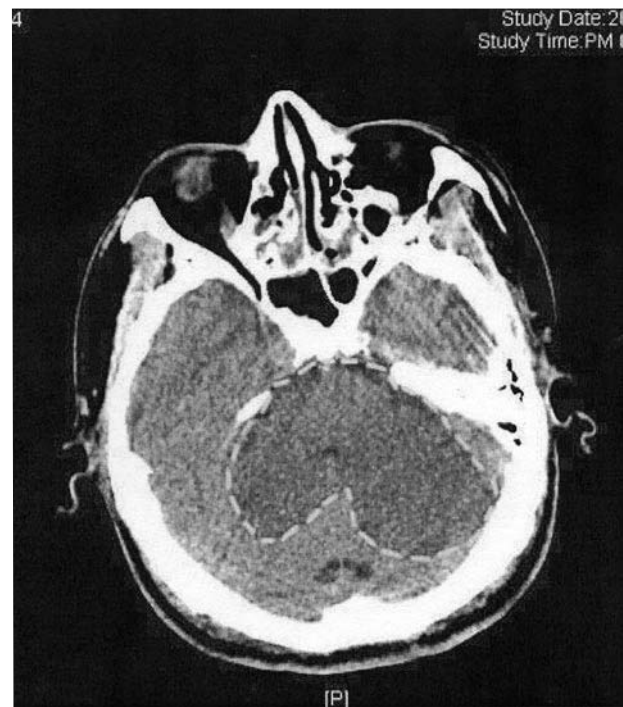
Postoperative brain computed tomography scan showed a low-intensity area, indicating a large brainstem infarction at the pons.
